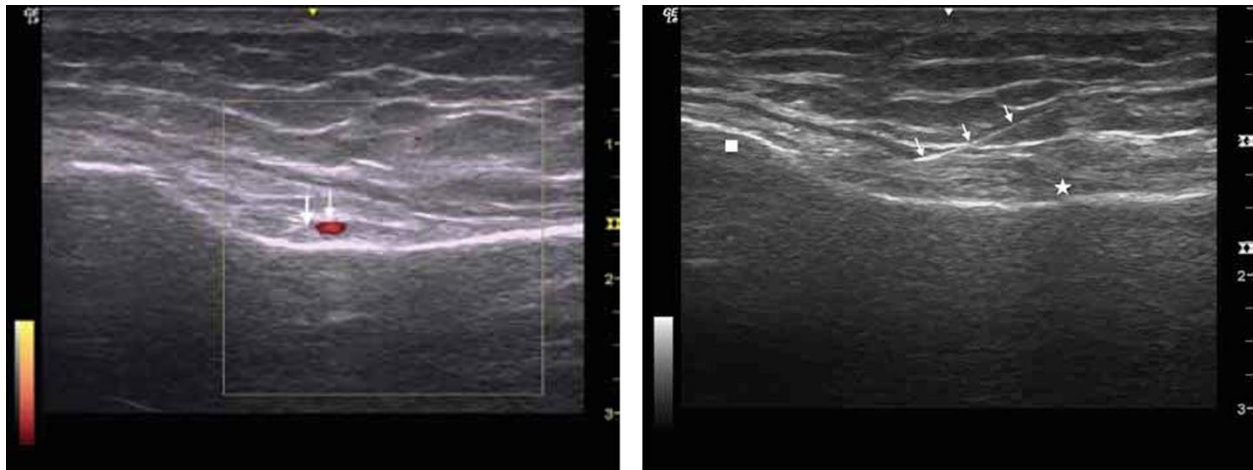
(a) knee ultrasound image taken longitudinally at the tibial medial epicondyle level. Power Doppler was used to visualize the inferior medial genicular nerve (thick arrow) and the artery that is connected to it (thin arrow). (b) For the inferior medial genicular nerve, The needle (arrows) was positioned at the bony cortex midway between the apex of the tibial medial epicondyle (square) and the initial fibers of the medial collateral ligament (star) that attach to the tibia. (Kesikburun et al., 2016).
